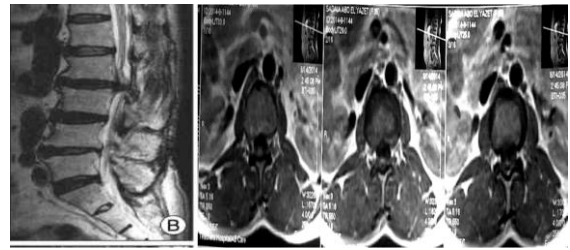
Preoperative MRI lumbar spine T2 axial and sagittal showing L2-3 disc prolapse
